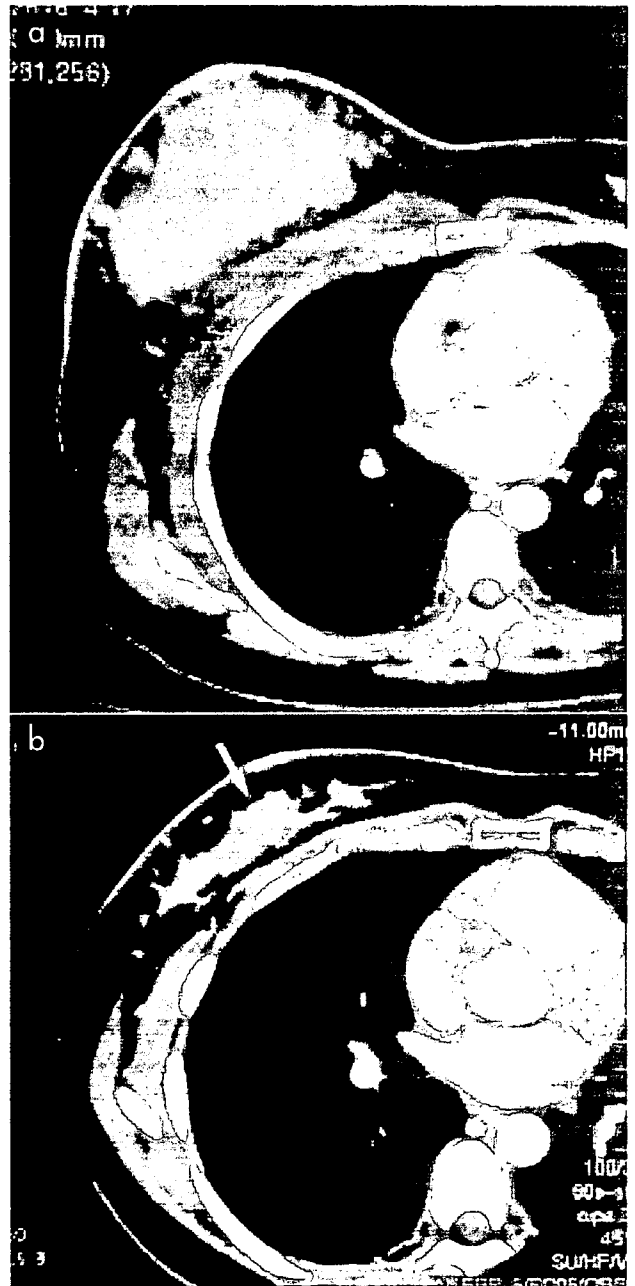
(a) CT shows a large right breast mass with overlying edematous subcutaneous tissue and thickened skin. This is not the early phase but late phase scan of breast CT, because only chest CT without an early phase scan was performed to detect distant metastasis instead of breast CT. (b) CT scan reveals a mass-like lesion measuring 3 cm, without enhancement, in the right breast.
